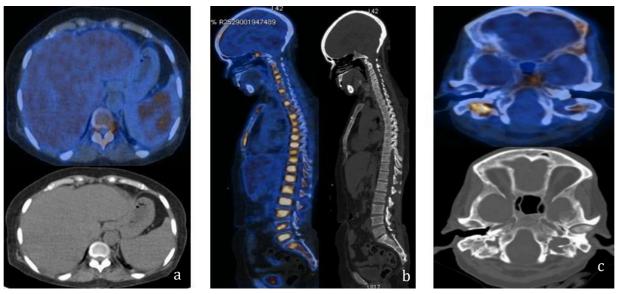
a.) Metabolically active, ill-defined hypodense lesions in the spleen, b.) Diffuse, intensely increased FDG uptake is seen in the axial and proximal appendicular bone marrow with no corresponding lytic/sclerotic lesions, c.) Patchy heterogeneously increased metabolic activity along the dura in bilateral frontal and parietal convexities.
